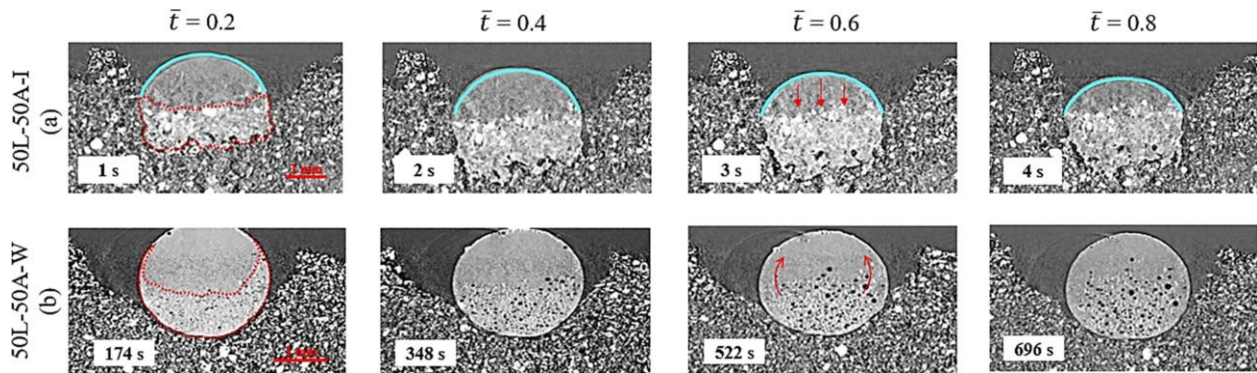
Time CT images of the droplet penetration at time points $t = 0.2, 0.4, 0.6,$ and 0.8 . (a) 50L-50A with isopropanol, droplet cap is shown by a blue line and the granule is forming beneath the bed surface. (b) 50L-50A with deionized water, powder covers the droplet and moves inward to form the granule [42].
